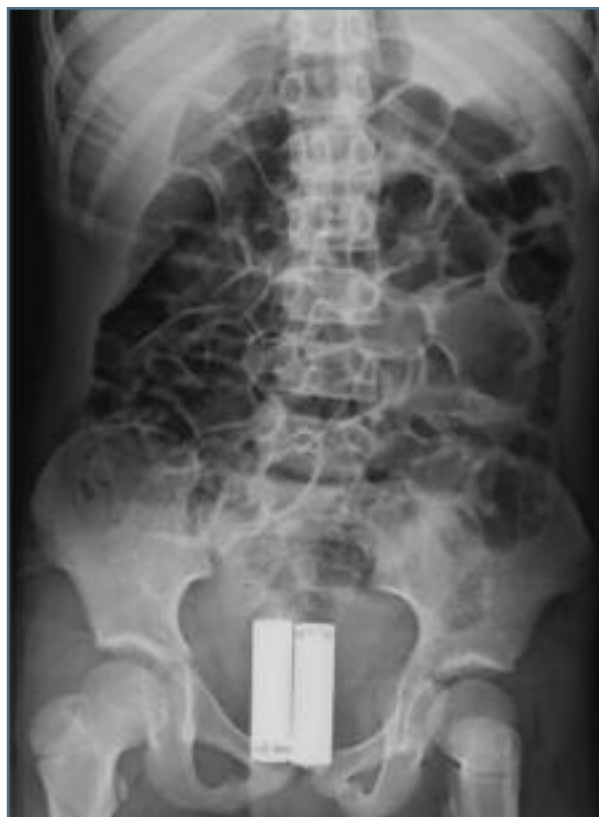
Abdominal X-ray revealing two parallel radio opaque foreign bodies in the vagina
